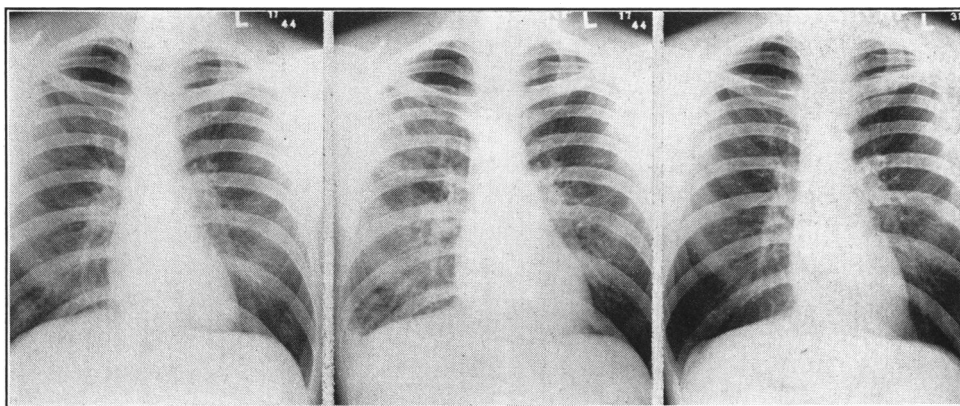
(Case No. 45). A moderately severe case of primary atypical pneumonia. After 2 intermittent periods of respiratory symptoms, this patient became ill with moderately severe atypical pneumonia on the 12th day, post-inoculation. Remittent fever persisted for 10 days. Patchy pneumonic infiltration of the entire right lung and left lower lobe were demonstrable in roentgenograms. Cold hemagglutinins were present in a maximum titer of 256 on the 25th day after inoculation, or 13 days after onset of illness. Streptococcus agglutinins increased to a titer of 16 at the same time and reached a titer of 32, 4 weeks later.
